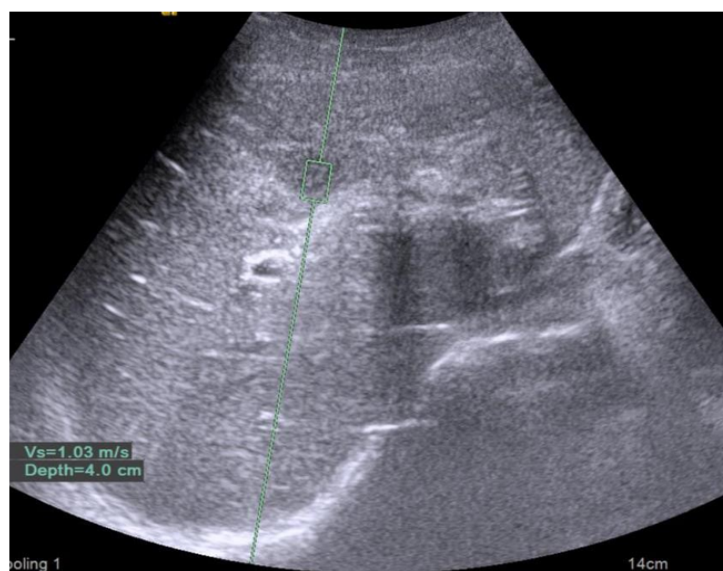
Ultrasound elastography in a hepatic adenoma
